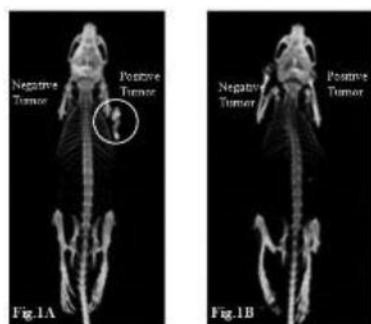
Representative SPET/CT images after intravenous administration of ^{123}I -scFvD2B.
